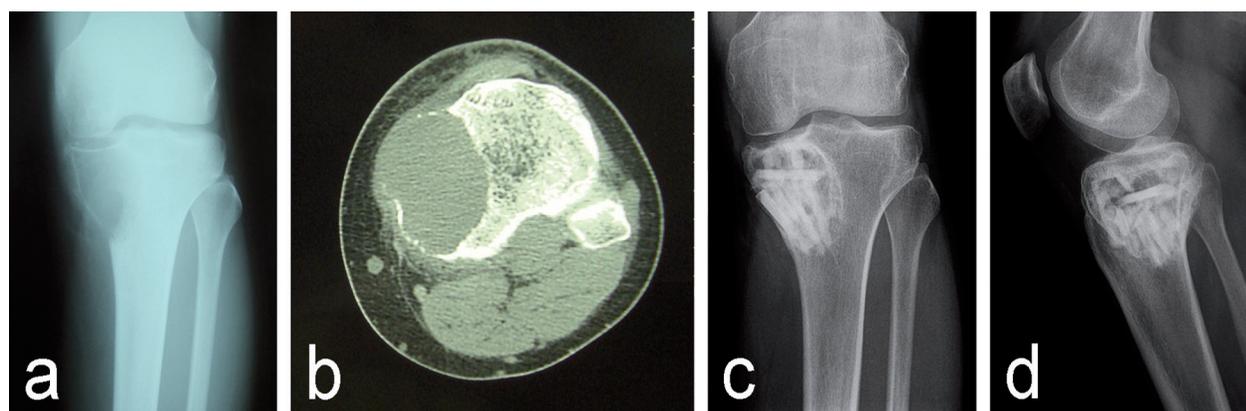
Preoperative AP radiograph (a) and CT (b) of a meta-epiphyseal GCTB of proximal tibia; c, d) AP and lateral radiographs after extended intralesional curettage and allografting with freeze-dried cancellous bone and cortical struts.
